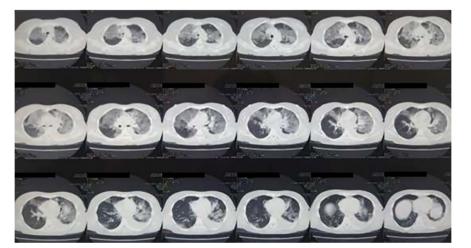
Computerized tomography (CT) of the chest without contrast. Multislice helical tomography of the chest and mediastinum with 5 mn slices and axial, sagittal, coronal and 3D multiplanar reconstructions, whose images show extensive lung lesions and moderate pleural effusion on the left.
